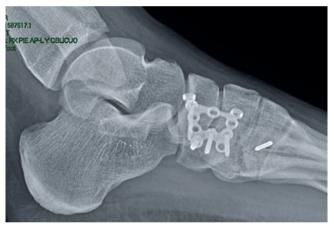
Postoperative radiograph showing reduced cuboid fracture.
